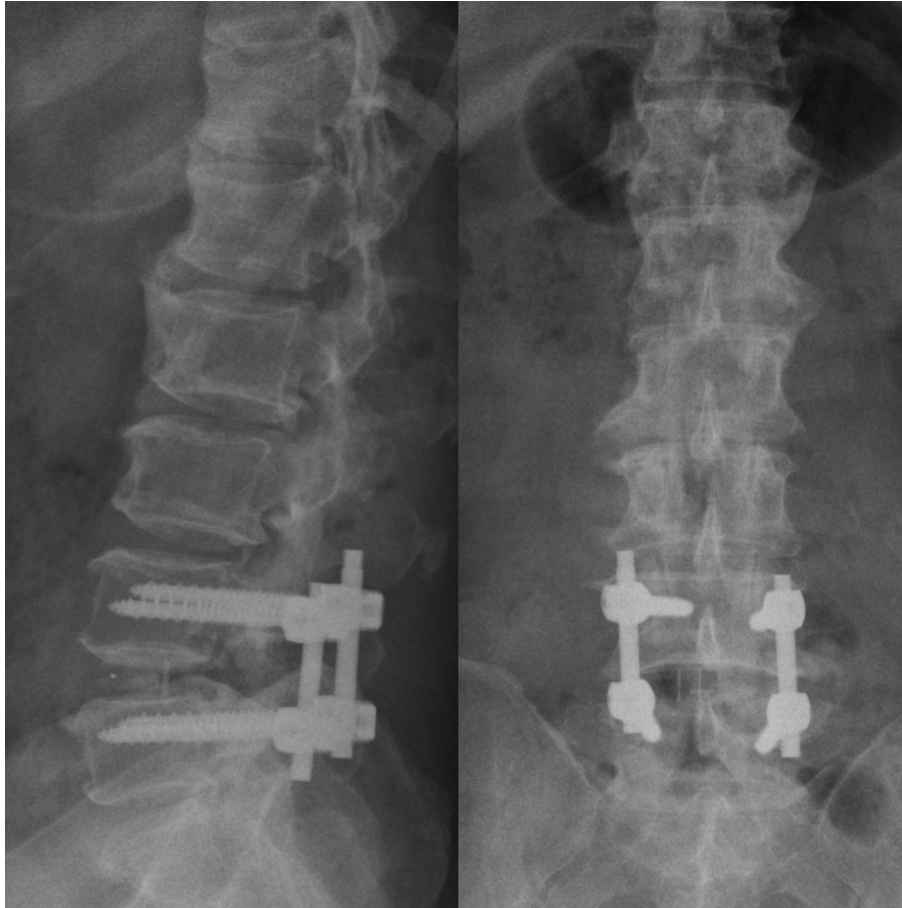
Postoperative lumbar X-rays
